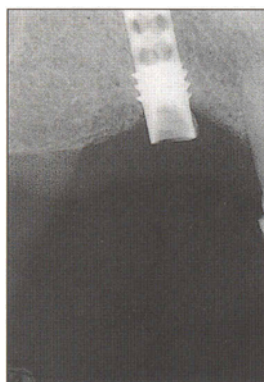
Periapical radiograph of the non-restorable hollow-basket implant.
